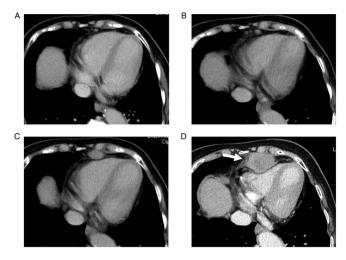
Computed tomography images. Axial images acquired using contrast-enhanced computed tomography (A) before colectomy, (B) six months after colectomy and (C) twelve months after colectomy. (D) Anterior mediastinal tumor compressing the heart 18 months after colectomy (indicated by arrow).
